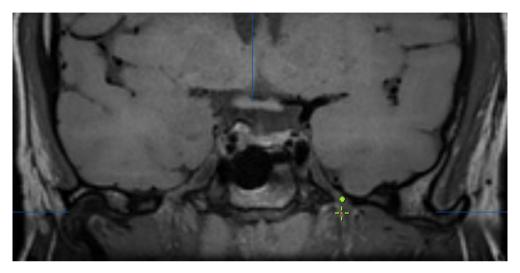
T1 image obtained with a 3-Tesla MRI machine in one of the patients in paper 4. The green dot is situated over the mandibular nerve. The green cross with a red dot in the center is situated over the expected location of the otic ganglion, directly medial of the mandibular nerve. A modified version of this imaged has been published by the author of this Thesis (139).
